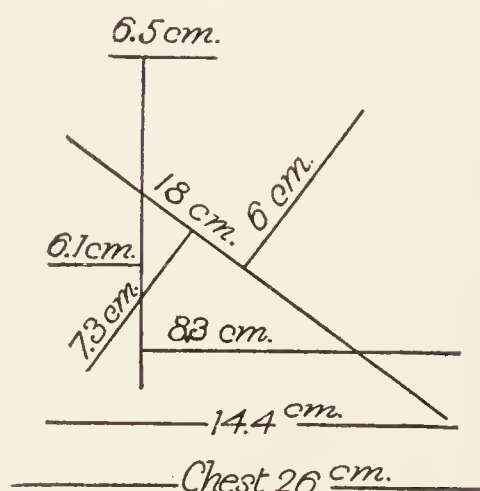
Measurements by X-ray.
